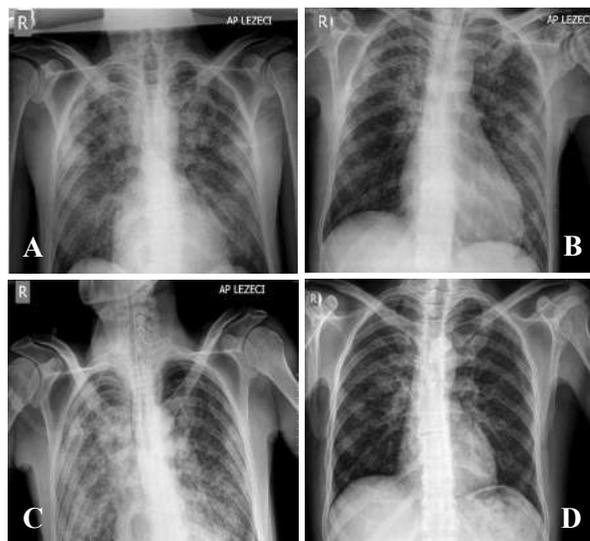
Chest x-ray A. on admission; B. regression of initial findings as a response to therapy (TMP-SMX, corticosteroids); C. development of new pulmonary changes during application of mechanical ventilation; D. on discharge.
